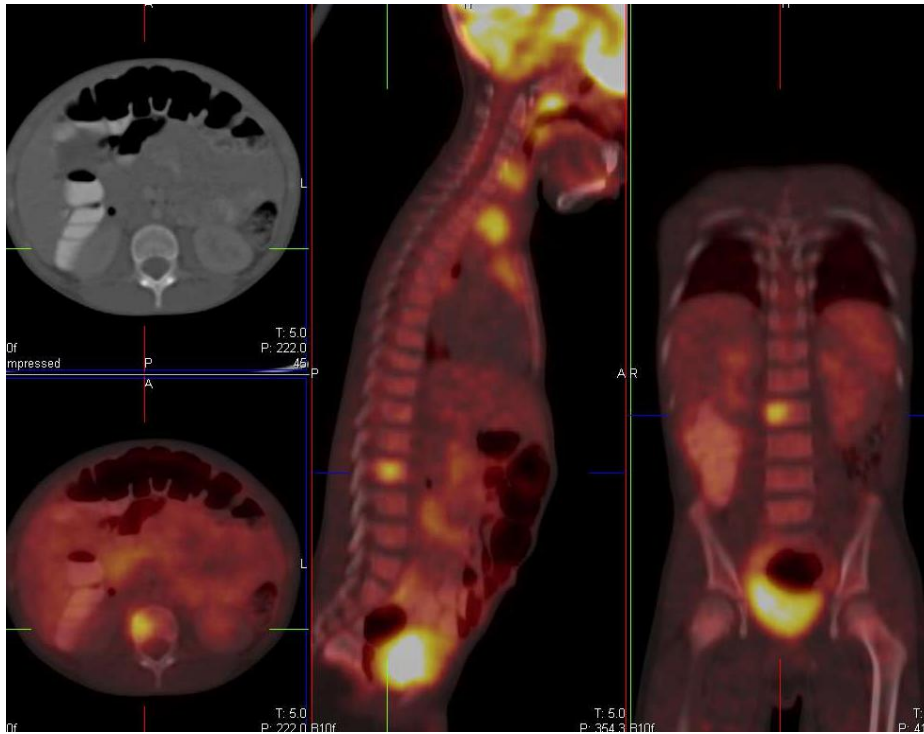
Patient R37, showing bone marrow infiltration in L2 vertebral body. There was no disease in the pelvis on FDG PET-CT. BMB did not demonstrate HL infiltration.
